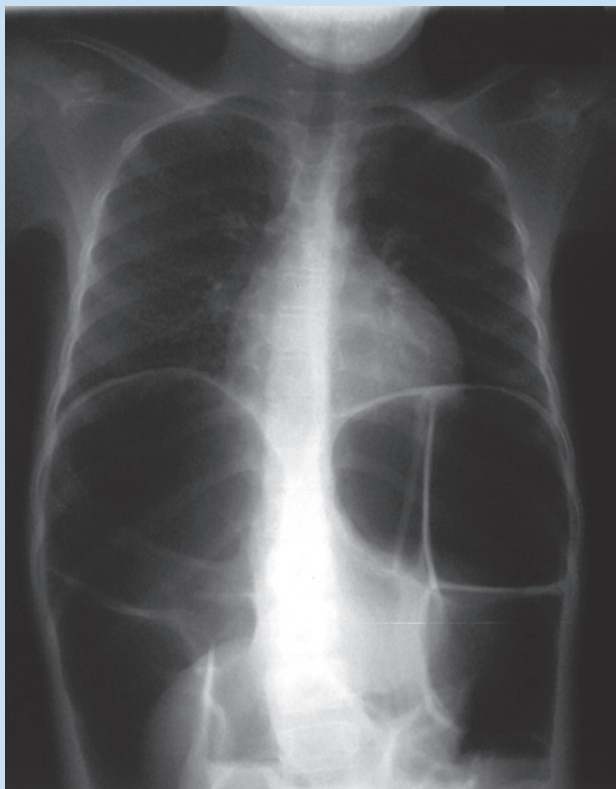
Chest X-ray of 9-year-old Sotho girl.
